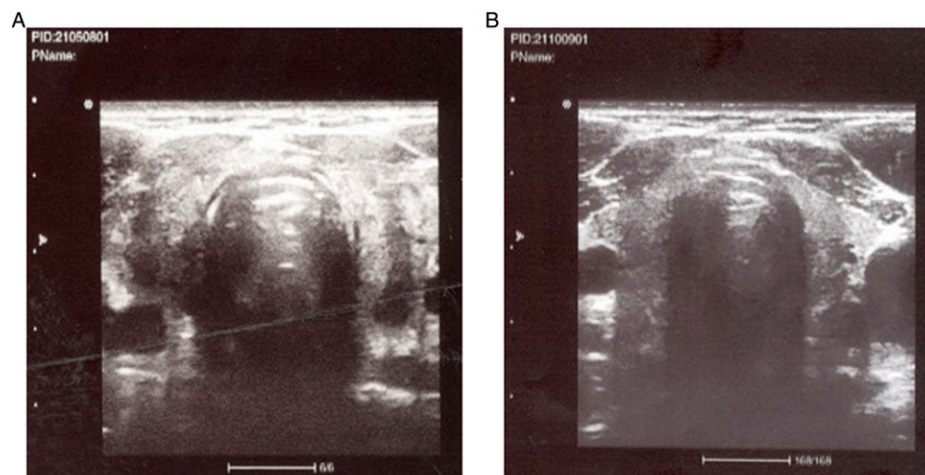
Thyroid gland in the transverse scan: (a) 4 months later, and (b) 6 months later. Ultrasonography of the thyroid gland was performed on the Toshiba Xario SSA-660A device by linear probe 7.5 MHz.
